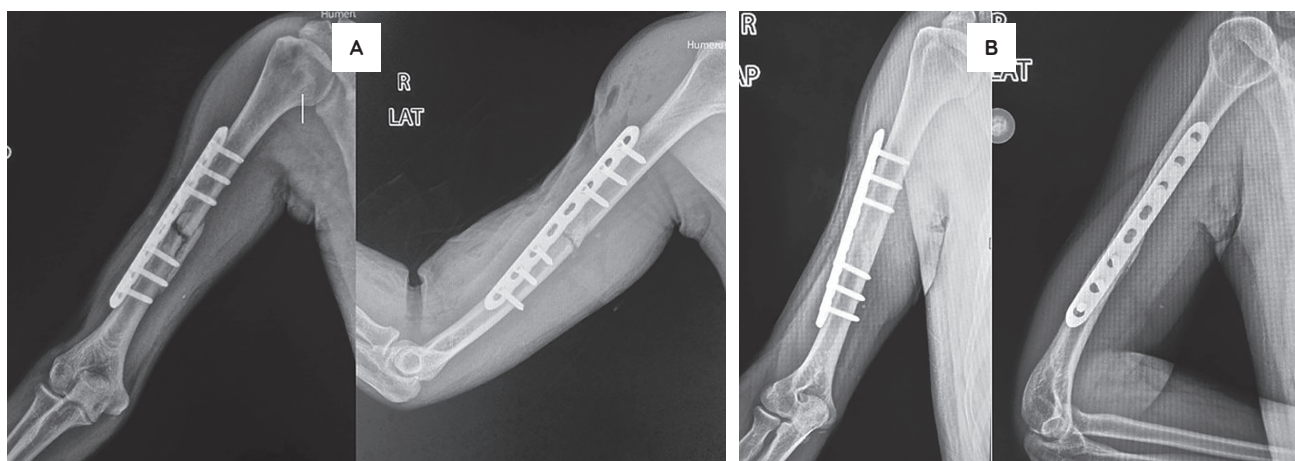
A 34-year-old male diagnosed with oligotrophic nonunion of the middle third shaft of the humerus 4 months post-operatively after serial radiographic monitoring. Pre-PRP Radiograph (A) reveals no progression of callus formation. Post-PRP Radiograph after 5 months (B) reveals absence of fracture line and recanalization.
